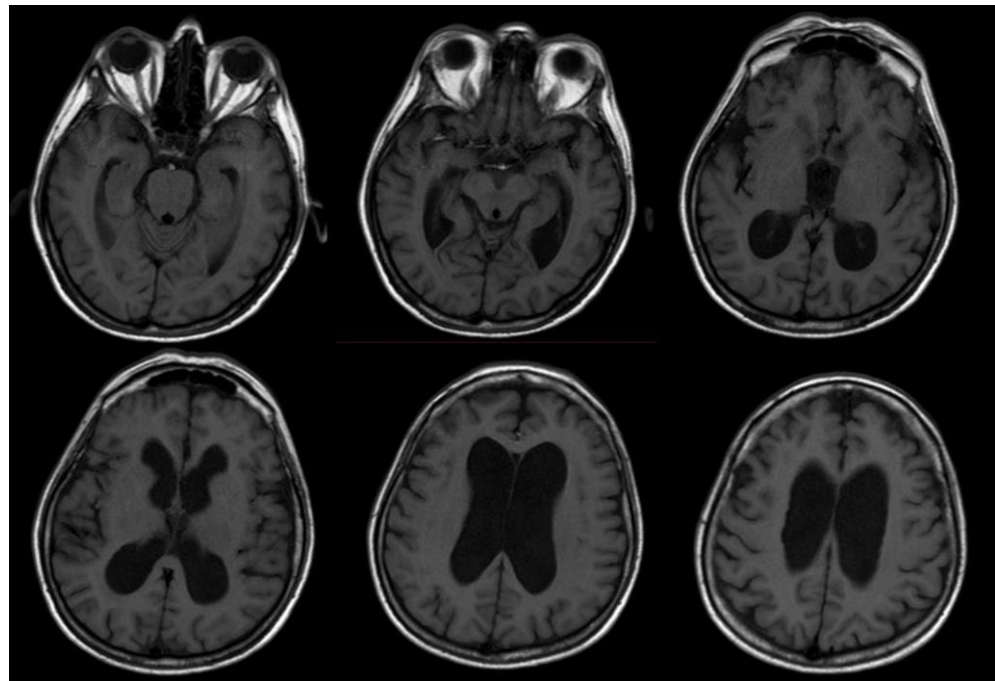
MRI allows to evaluate degree and location of the dilatation of the ventricular system.
